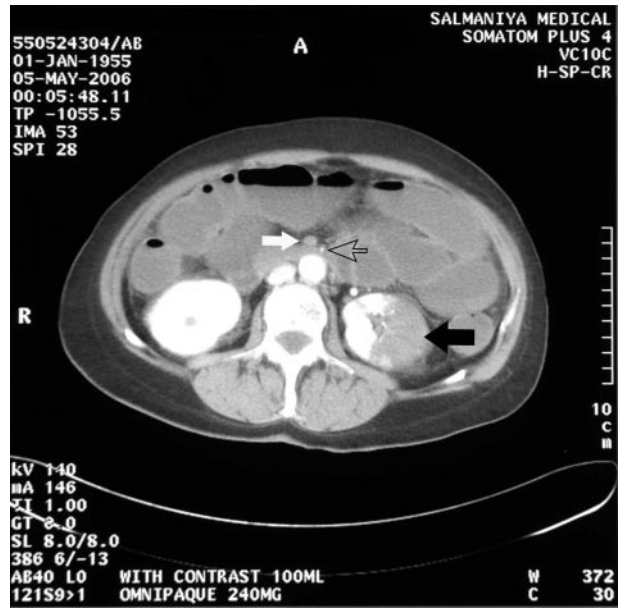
CT scan of the abdomen on ICU admission (arrows point to abnormalities).
